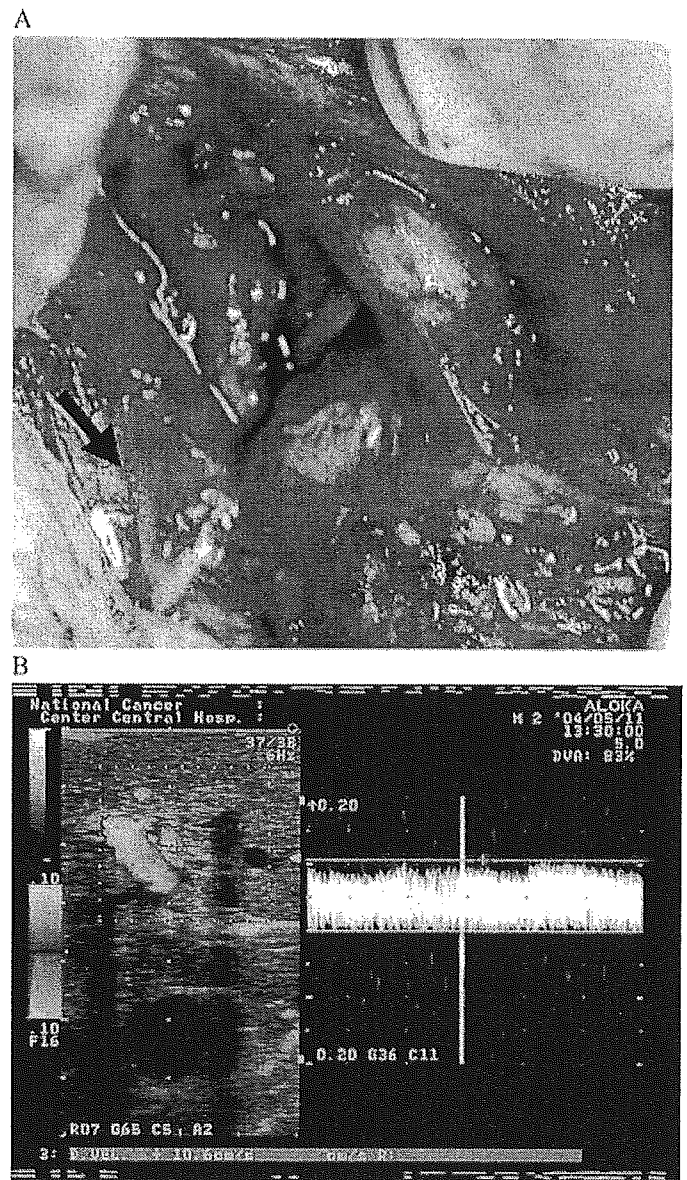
A. The median arcuate ligament (arrow) masking the root of the celiac axis. B. After clamping of the gastroduodenal artery, intraoperative Doppler ultrasonography revealed an apparent decrease in the intrahepatic arterial flow.
